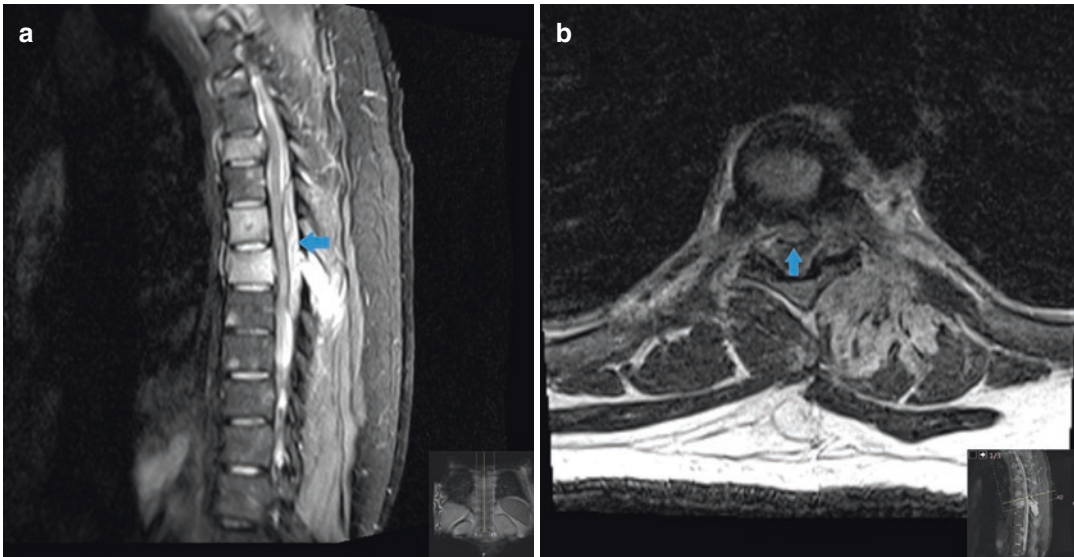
Dysplastic small round cell tumor Figure 9.2a is a sagittal fat-saturated postcontrast T1-weighted MR image showing a dorsal epidural tumor in the mid-thoracic spine, causing mass effect on the thoracic cord (arrow). There are also osseous metastases. Figure 9.2b is
